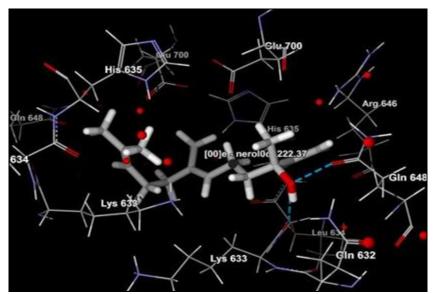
DOCKED VIEW OF [00] E-NERODILOL USING LIGAND ENERGY INSPECTOR
